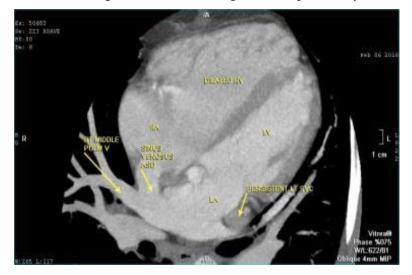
multi slice CT, showing the connection of right superior pulmonary veins to the SVC (PAPVD).
